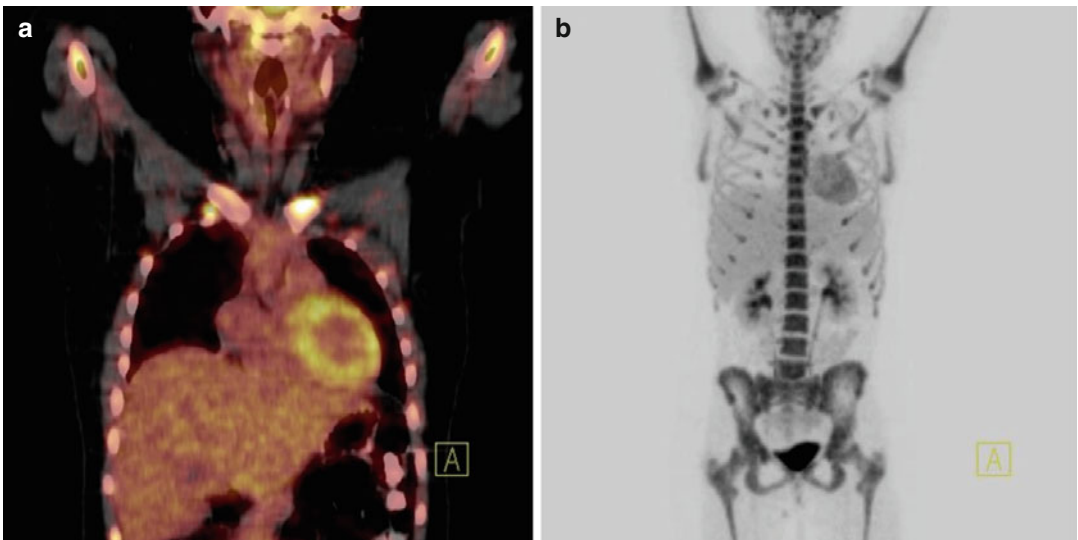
Interim PET/CT (a, b), after two chemotherapy cycles, shows complete remission of the disease. The hypermetabolic visualization of the bone marrow is attributed to G-CSF administration
